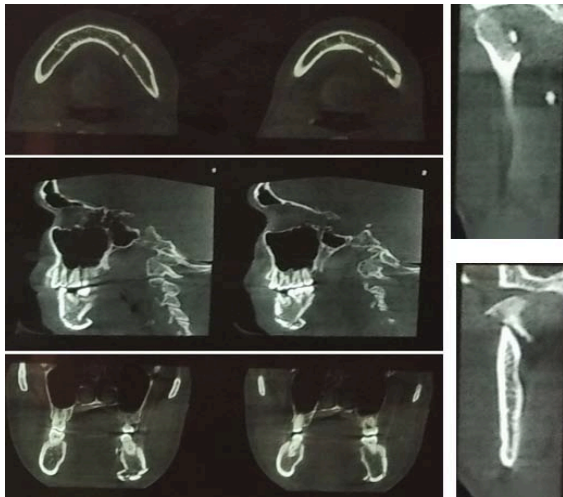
Axial, sagittal and coronal CBCT view shows comminuted fractures
